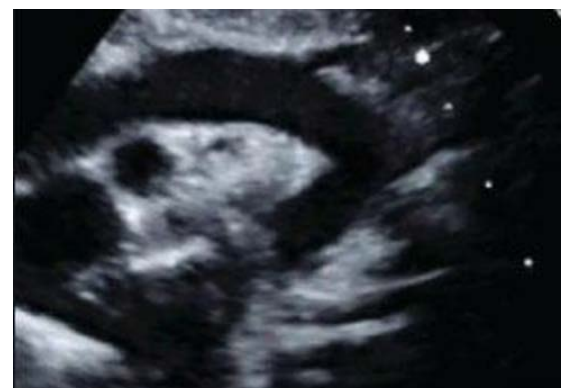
The post-repair echocardiography shows a normal right side aortic arch with no apparent residual lesion from resected small left side aortic arch.
